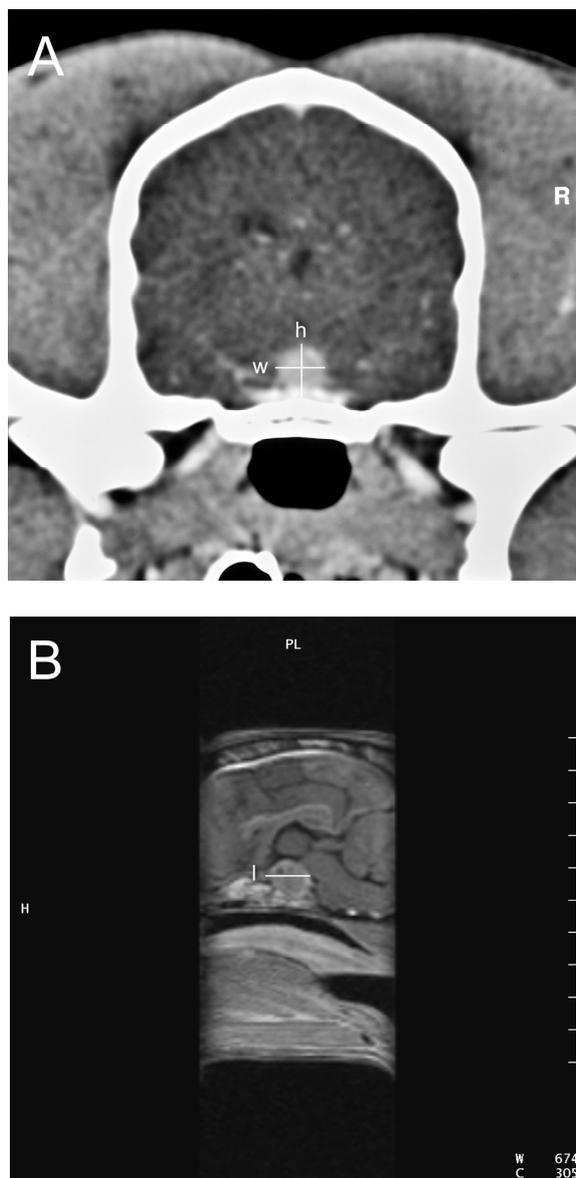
Measurements of pituitary dimensions (height, width, and length) in contrast-enhanced computed tomography (CT) (A) and magnetic resonance (MR) (B) images. (A) Transverse CT image: measurement of the pituitary height (h) and width (w) on transverse images. (B) Sagittal MR image: measurement of the pituitary length (l).
